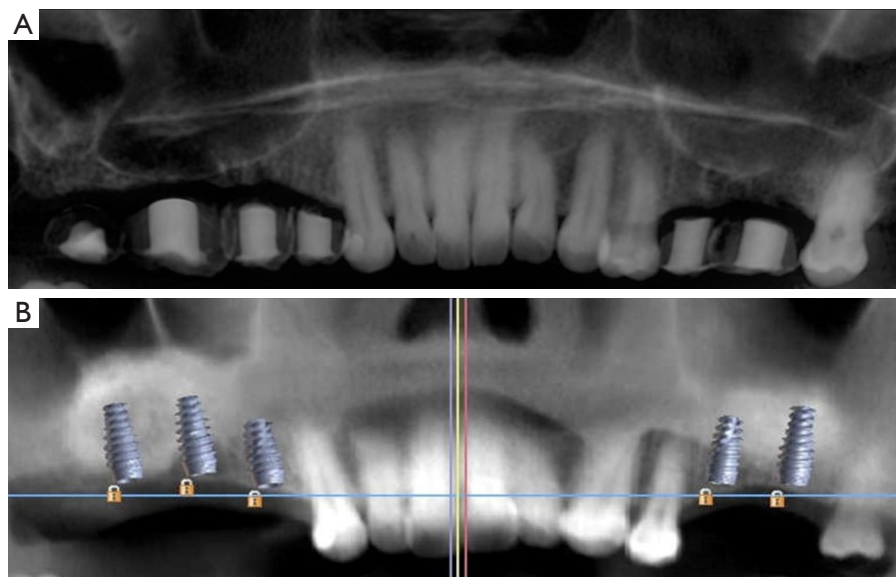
Cone-beam computerized tomography assessment. (A) Preoperative panoramic projection. (B) Postoperative panoramic projection.
